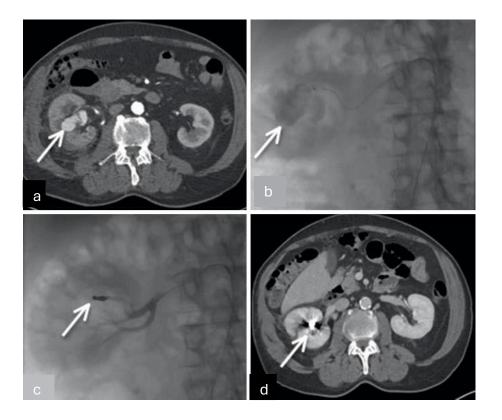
A - Contrast-enhanced CT demonstrating a renal artery pseudoaneurysm (white arrow) of 4.4 × 2.3cm after partial nephrectomy on the right side. B - Angiography confirms the pseudoaneurysm (white arrow) of the upper renal artery. C – Successful embolisation of the feeding vessel of the pseudoaneurysm with six microcoils, which were deployed via a co-axial microcatheter system. D - Postinterventional CT demonstrating complete occlusion of the feeding vessel of the vascular lesion with microcoils.
